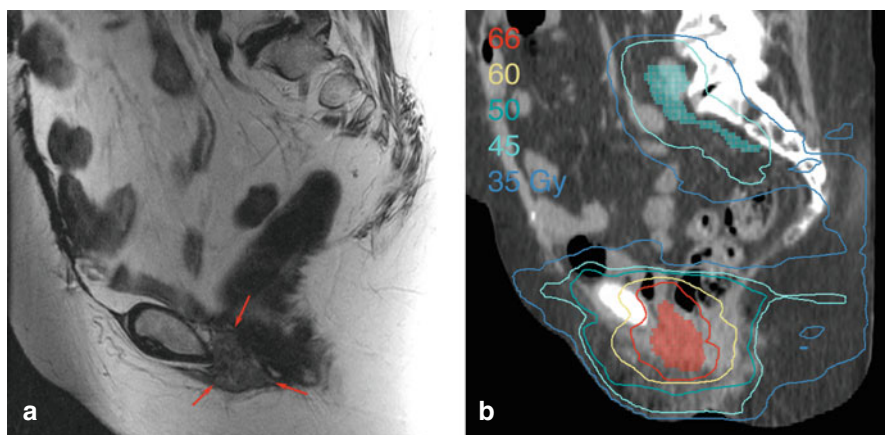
Locally recurrent clear cell carcinoma of the urethra after surgical resection. A 73-year-old woman initially had a 3 cm urethral mass that was treated with cystourethrectomy, ileal conduit formation, and pelvic lymphadenectomy. Clear cell carcinoma involved the periurethral soft tissue, and there was lymphatic space invasion, but the surgical margins and all nodes were negative. Five years later, she noted a mass in the anterior vestibule of the vagina, which was biopsied showing recurrent clear cell carcinoma. On MRI, there was multifocal recurrence with a 3×4 cm mass in the right retropubic soft tissues (a) and 1.5×3 cm nodule in the left ischioirectal fossa. The patient was treated with concurrent weekly cisplatin and radiation therapy (b). At 2 years, she has no evidence of disease
